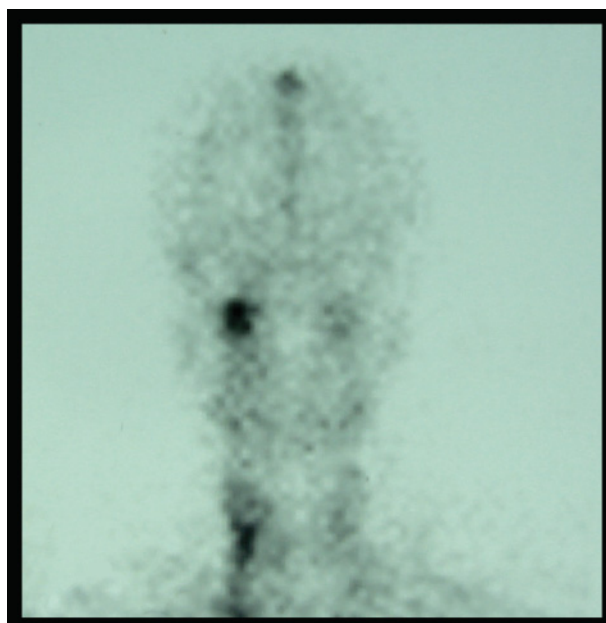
Skull and neck (posteroanterior view) scintigraph demonstrating a unilateral area of intense imaging ('hot' condyle), which is evidence of active condylar growth.
